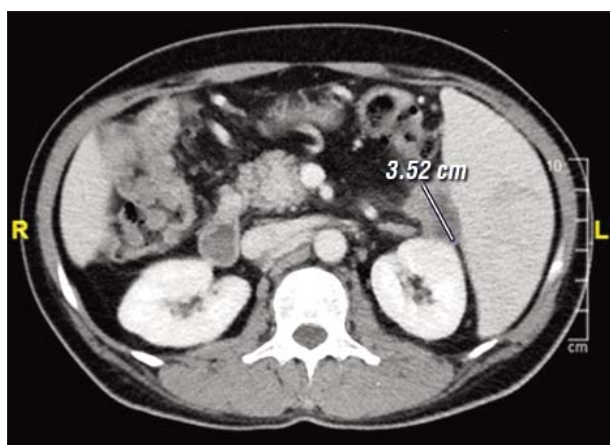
Staging CT scan after the neoadjuvant treatment showing the tumor mass at the pancreatic tail. The maximum diameter is 3.52 cm.
